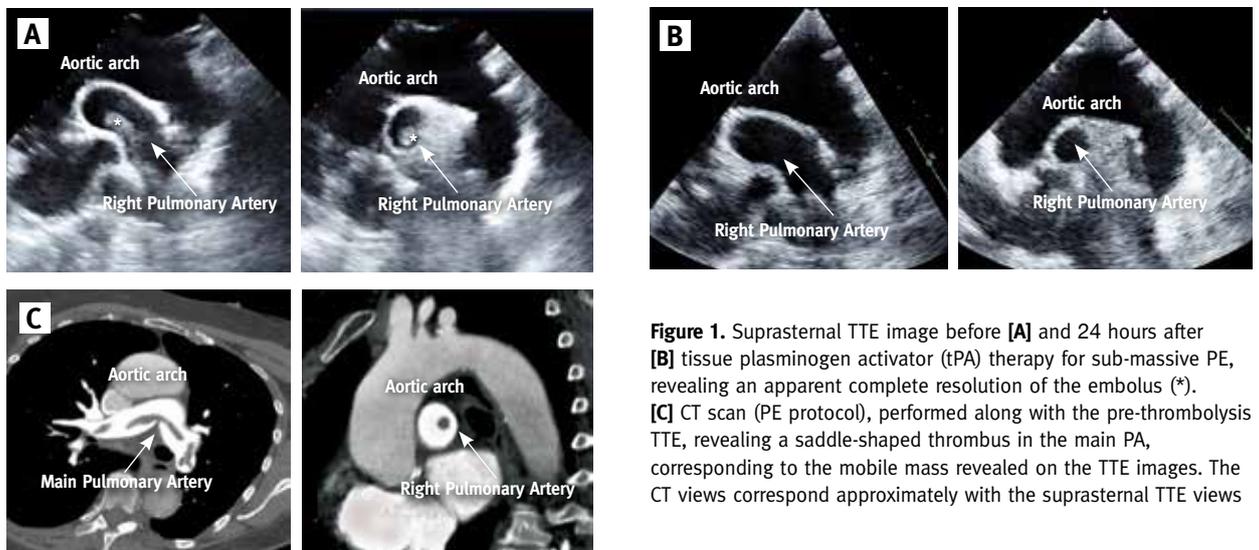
Suprasternal TTE image before [A] and 24 hours after [B] tissue plasminogen activator (tPA) therapy for sub-massive PE, revealing an apparent complete resolution of the embolus (*). [C] CT scan (PE protocol), performed along with the pre-thrombolysis TTE, revealing a saddle-shaped thrombus in the main PA, corresponding to the mobile mass revealed on the TTE images. The CT views correspond approximately with the suprasternal TTE views
